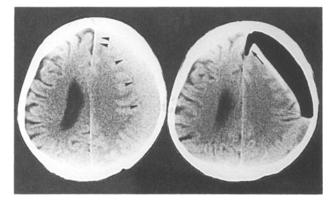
Pre-(left) and postoperative (right) computed tomography scans in an interhemispheric type. Note the location of the haematoma (arrowheads) involving the interhemispheric space, and oxygen in the interhemispheric region (arrow), showing the feature of the peaking sign
